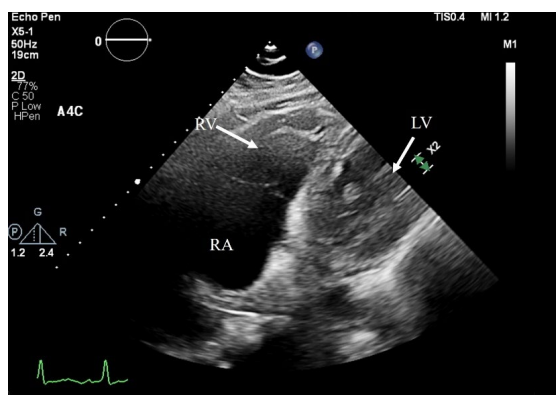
Echocardiogram post procedure demonstrates resolution of the clot in transit, TV (tricuspid valve), RV (right ventricle), and LV (left ventricle).
